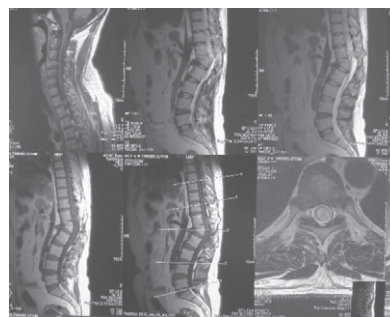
MRI (T1-weighted sagittal image) showing stenosis at LV1 and holocord syrinx
